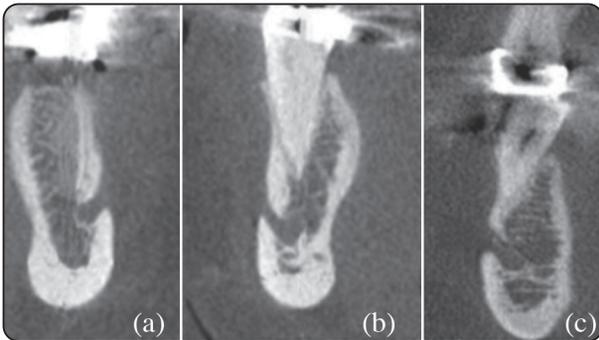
CBCT cross sectional cuts showing the morphology of mandibular cortices (CTCI).
